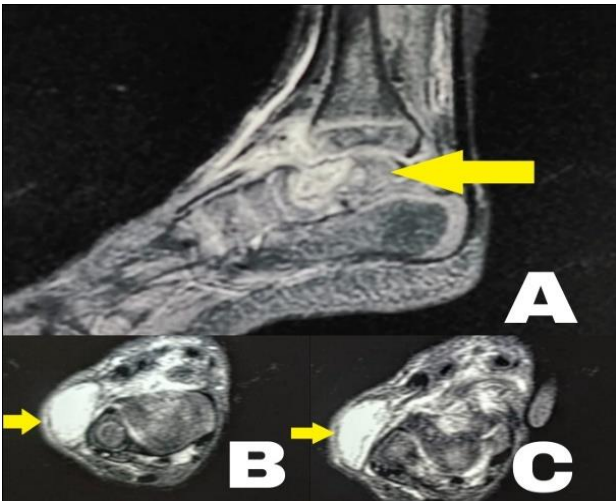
(A-C): Sagittal MRI cuts show destruction of the talus with a hyper-intense lesion involving the talus. A localised hyper-intense collection measuring about 2.5×2.3×1.1 cm is seen in lateral soft tissues.
